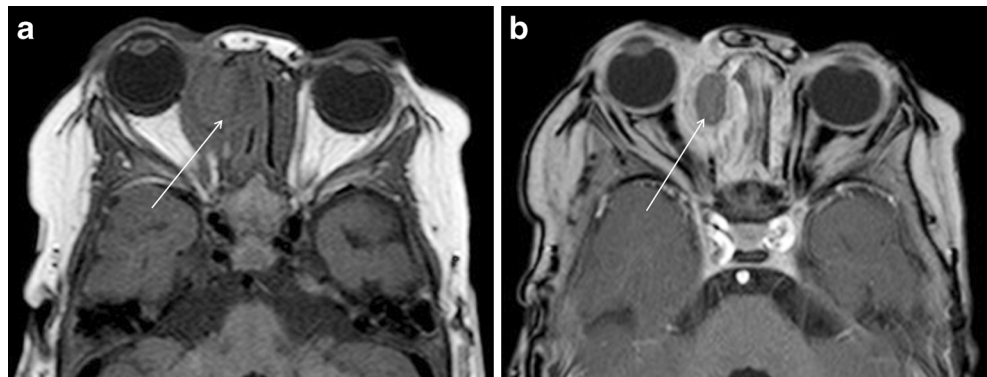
Post-treatment follow-up MRI orbits 4 months later. Axial (a) and coronal (b) T1-W post-contrast images demonstrate interval improvement with a decrease in the size of the peripherally enhancing right orbital tumor (arrows)
